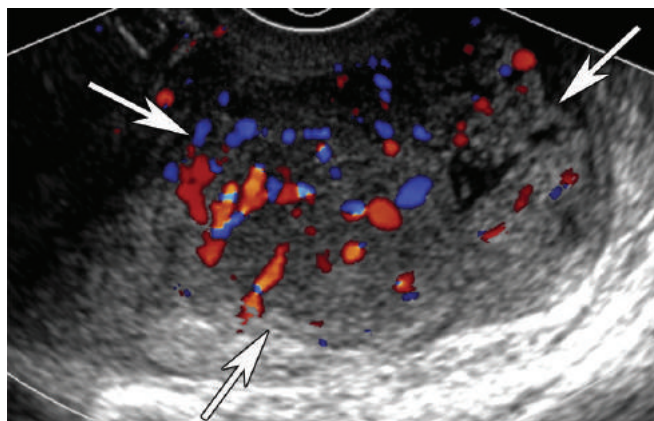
Sagittal endovaginal ultrasound showing a cervical cancer (arrows) that is causing distortion of cervical canal architecture and abnormal echotexture and demonstrates hypervascularity on colour Doppler evaluation.
